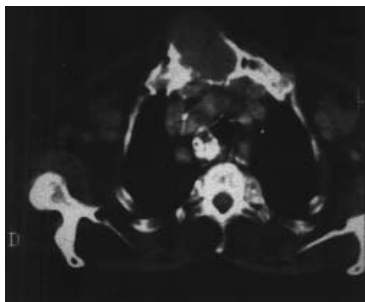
CT scan of sternal tumour
